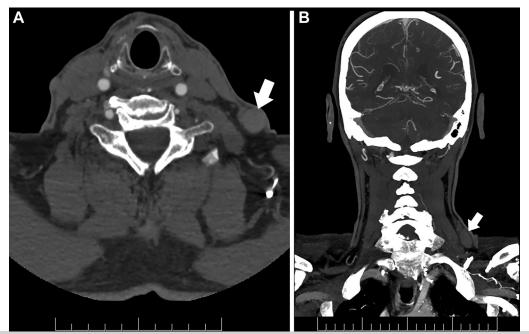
Coronal (A) and axial (B) computed tomography angiograms demonstrating a 1.6×1.5 -cm spherical mass contiguous with the external jugular (EJ) vein (*white arrow*).
